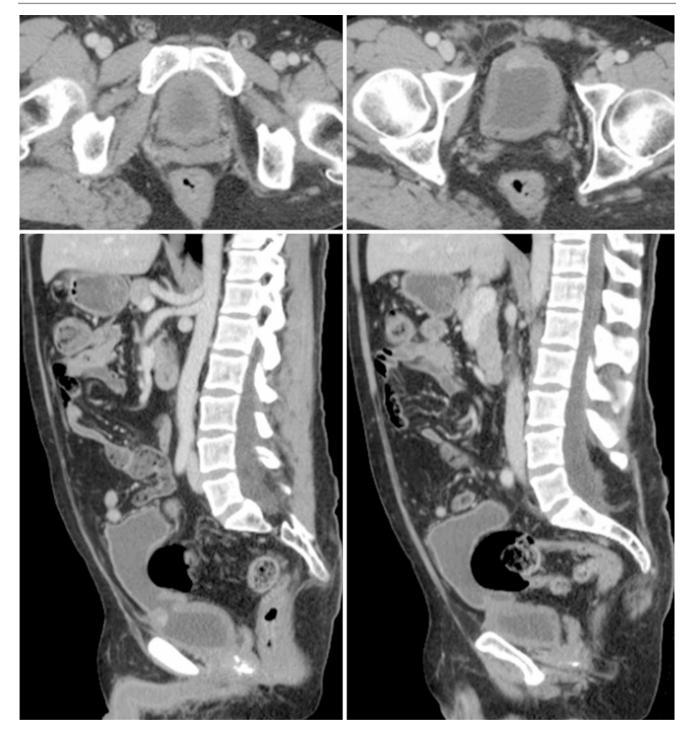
CT Scan of patient with hematuria and bladder augmentation (ileum) done 22 years before. A tumor can be seen at the bladder-intestine transition
